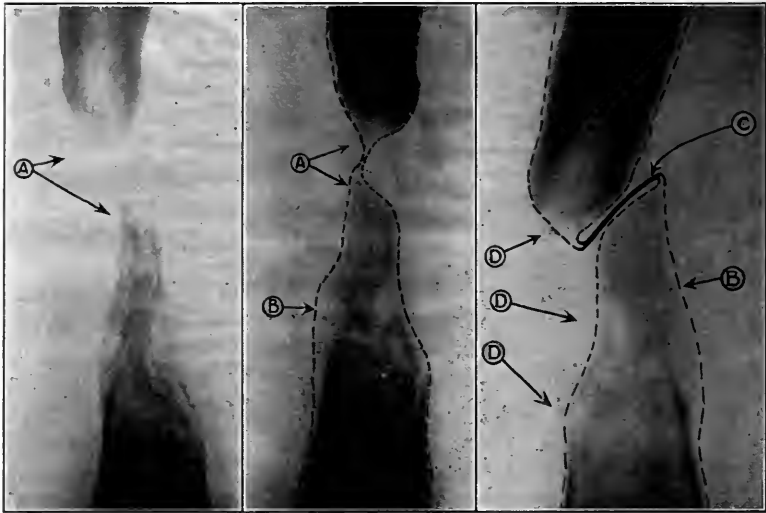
X-ray: Non-union and beginning pseudarthrosis. A, indicates the medullary callus which might have united if no gap had existed. Note the progressive rarefaction of both bone and callus. B, represents the periosteum. C, represents the adherent layers as shown at operation. The author's explanation of the cause of non-union in this case follows: There being no fragments left to hold the periosteal lumen open, the inward pressure of the surrounding soft parts occluded the periosteal tube. After three or four months the periosteum grew together obliterating its lumen. Periosteum being a limiting membrane, prevented the new calluses from joining together. Shortening was permitted too late. This new double layer of collapsed periosteum devoid of lumen folded upon itself leaving two semi-closed synovial cavities. This explanation uses the only positive function attributed to periosteum, *i. e.*, the limitation of bone-growth. The fact that the medullary callus had grown two inches from the lower fragment shows that bone formation itself was unimpaired. The stream-line taper of the ends of the callus indicates the natural line that a flexible tube assumes when subjected to uniform peripheral compression. Note the progressive atrophy of disuse.
